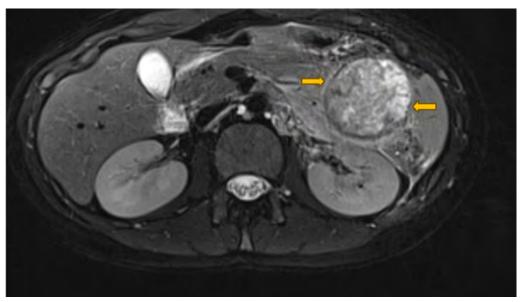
Abdominal MRI-scan showing a thick wall complex mass in the tail of the pancreas.
